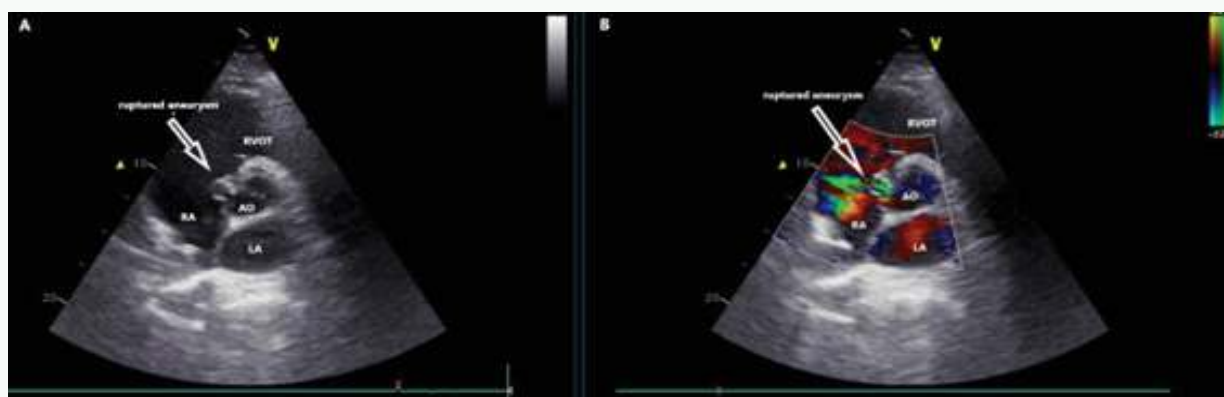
Parasternal short axis view of the transthoracic echocardiogram. The white arrow indicates the aneurysm (A) and shunt from the aorta to the right atrium (B).
